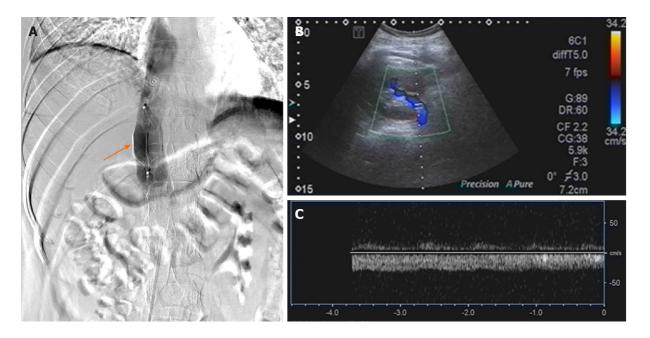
Renovascular ultrasound obtained 1 wk later (after filter implantation) confirmed that the thrombus of the right renal vein had resolved. A: Retrievable permanent filter implanted within the inferior vena cava, cephalad to the renal vein; B and C: Renovascular ultrasound (1 wk postimplantation) confirming resolution of the right renal vein thrombus and normalization of kidney size.
